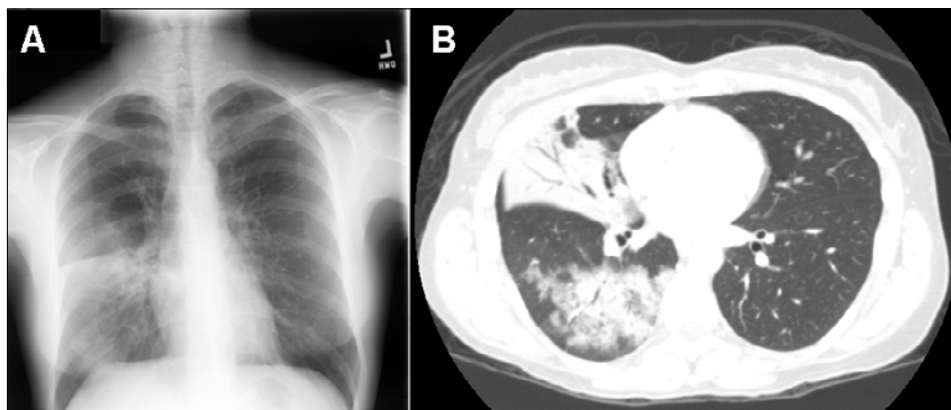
A) Chest x-ray showing right middle lobe and part of right lower lobe infiltrate. B) Computed tomography of the chest showing dense consolidation with air bronchogram in the right middle and lower lobe of the lung.
